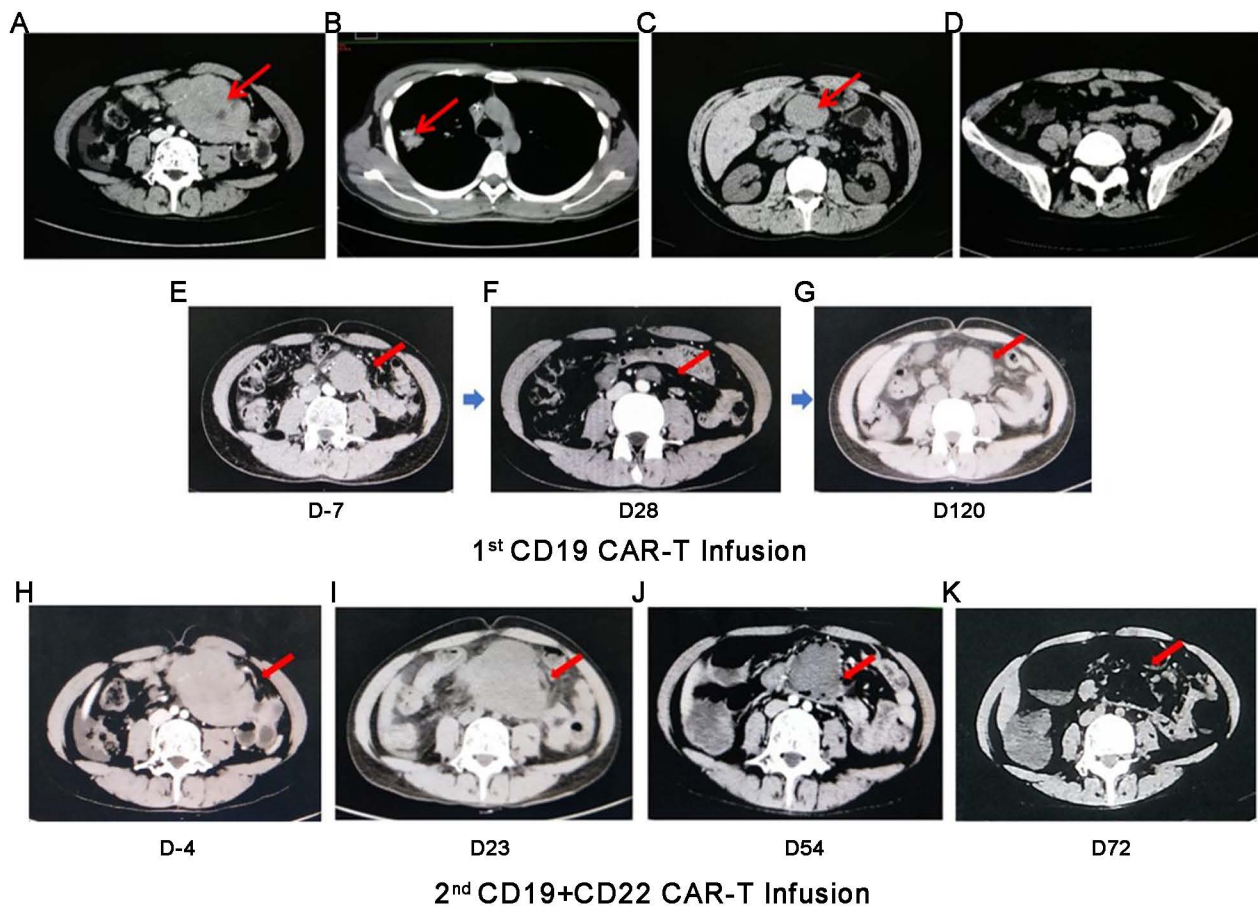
Axial images of CT chest and abdomen scan after two rounds of CAR-T infusion. (A) Imaging studies showed a large mass-like conglomerate with a maximum length of 13 cm in the patient's abdomen. (B) Chest CT scan showed the shadow of the right upper lobe of the lung. (C) The imaging showed that the abdominal mass was $\sim 7.6 \times 5.1$ cm. (D) The patient's tumor burden decreased. (E) Full-body CT scans revealed enlarged mesenteric lymph nodes located in the abdomen compared with the CT scans before CAR T-cell infusion. (F) On day 28 post-infusion, imaging showed that enlarged lymph nodes in the abdominal cavity were smaller. (G) On day 120 post-infusion, imaging showed a conglomerate mass with a maximum length of 4.89 cm in the patient's enterocoelia. (H) Imaging before the second CART treatment showed that the abdominal mass was significantly larger than before. (I) Full body CT scans on day 23 revealed that the abdominal mass had increased in size (maximum diameter, 9 cm). (J) There was a marked reduction in the size of the abdominal mass after 54 days. (K) A full-body CT scan on day 72 demonstrated complete remission. CT, computed tomography.
